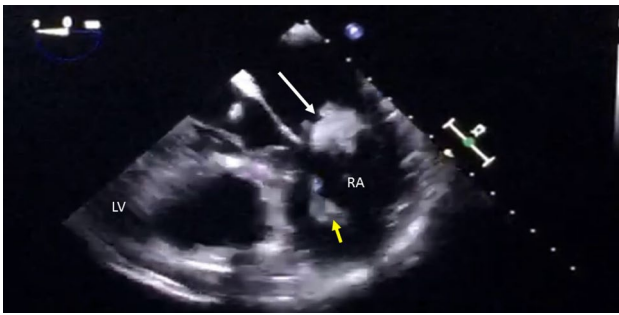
Transthoracic echocardiograms showing large intracardiac vegetation of tricuspid valve in a young intravenous drug abuse patient (white arrow). The vegetation is the cause of valvular stenosis. The yellow arrow shows interatrial thrombus formation.
